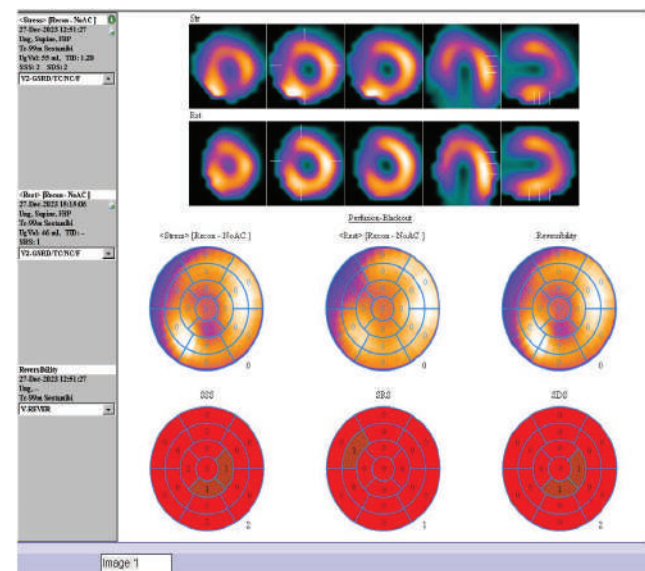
^{99m}Tc -sestamibi gated SPECT Myocardial perfusion scan image showing normal perfusion.
